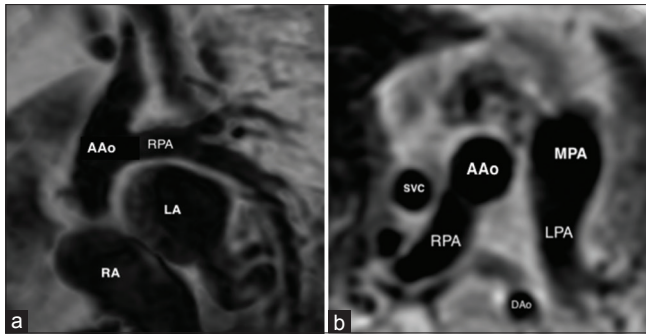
Sagittal (panel a) and axial (panel b) magnetic resonance imaging views acquired on Case number 4 using black-blood sequences clearly show disconnected branch pulmonary arteries with the right pulmonary artery arising from the mid-ascending aorta. Left pulmonary artery is in continuity with the anatomical main pulmonary artery
